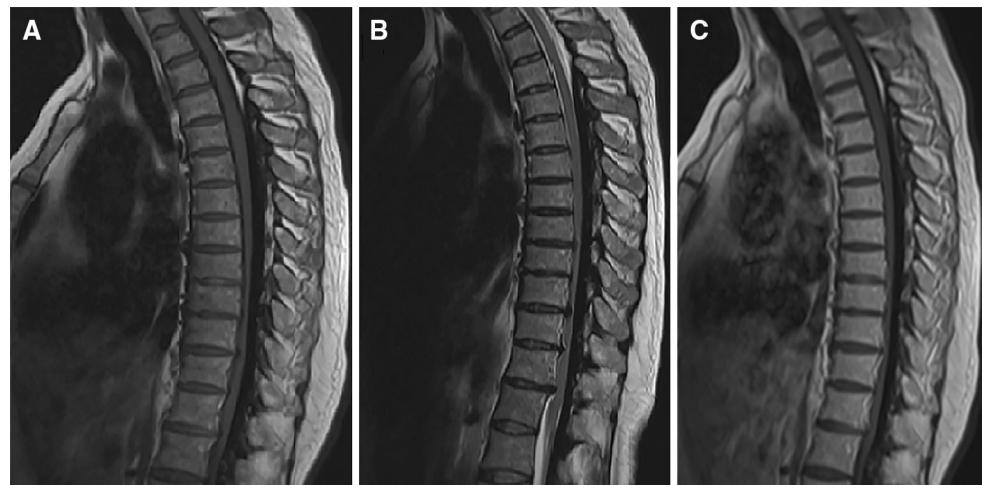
Magnetic resonance images. Sagittal images showed low signal intensity on T1 (a) and T2 (b) weighted images and non-enhancement on T1 weighted-enhanced images (c)
